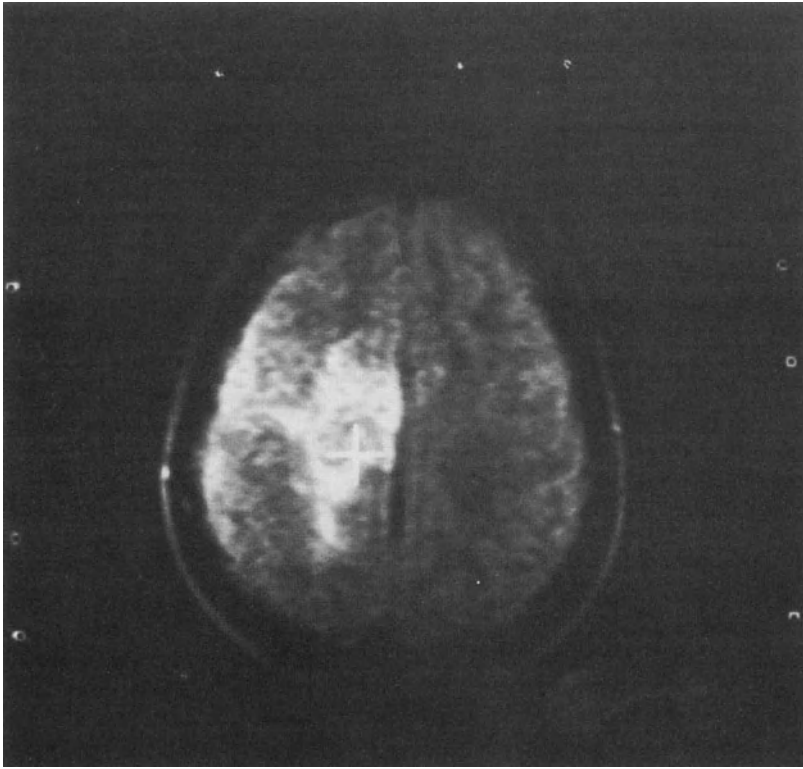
Digitizing target point on stereotactic MRI in patient with grade III astrocytoma in right medial central area.
